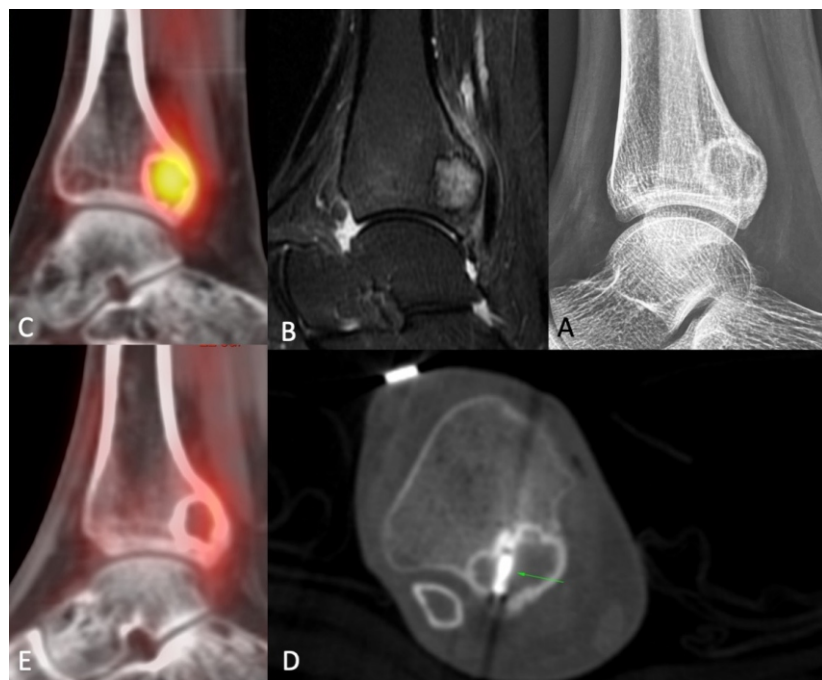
(A-E). Cryoablation of chondroblastoma. X-ray (A), sagittal T2 MRI (B) and PET (C) show typical features of a distal tibial chondroblastoma in a 20-years old. A 3-3-5 freeze-thaw-freeze cycle was used during the cryoablation (D) with a 13 G probe and intravenous sedation. The post-procedure PET (E) done 10 days later shows complete lack of FDG uptake. The patient was asymptomatic.
